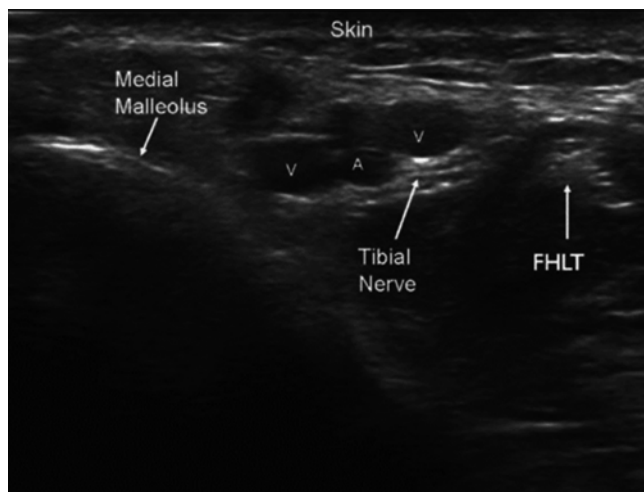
Ultrasound anatomy of the tarsal tunnel at the level of the ankle (short axis view). A posterior tibial artery, *FHLT* flexor hallucis longus tendon, *V* vein. Screen right is posterior, and screen left is anterior. Note the vein-artery-vein configuration near the nerve and the proximity of the flexor hallucis longus tendon (*FHLT*); the latter can be distinguished from the nerve by watching it move when the great toe is flexed (From Redborg et al. [38]. Reprinted with permission from Wolters Kluwer Health, Inc)
